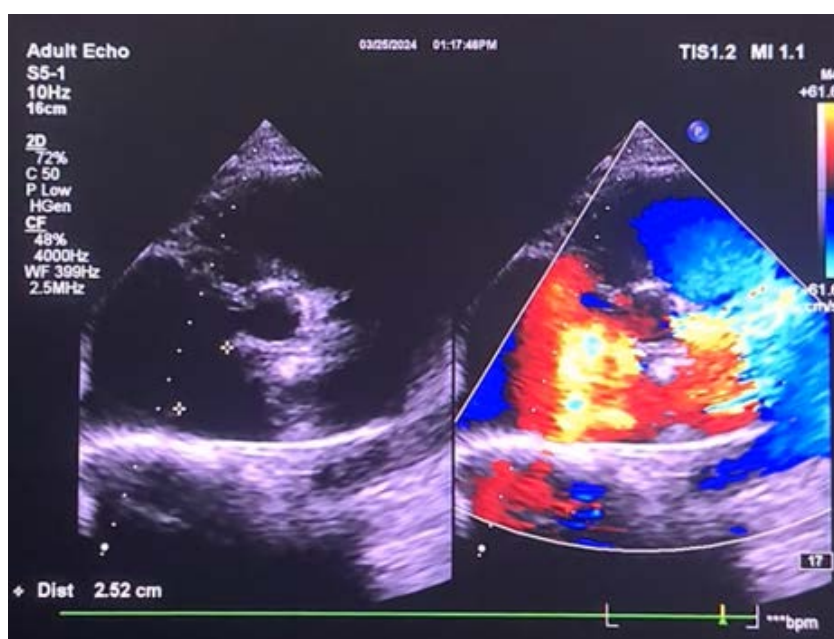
Echocardiography. Parasternal Short Axis (PSSA) Aortic Valve Level .L-R Shunt due to Atrial Septal Defect
